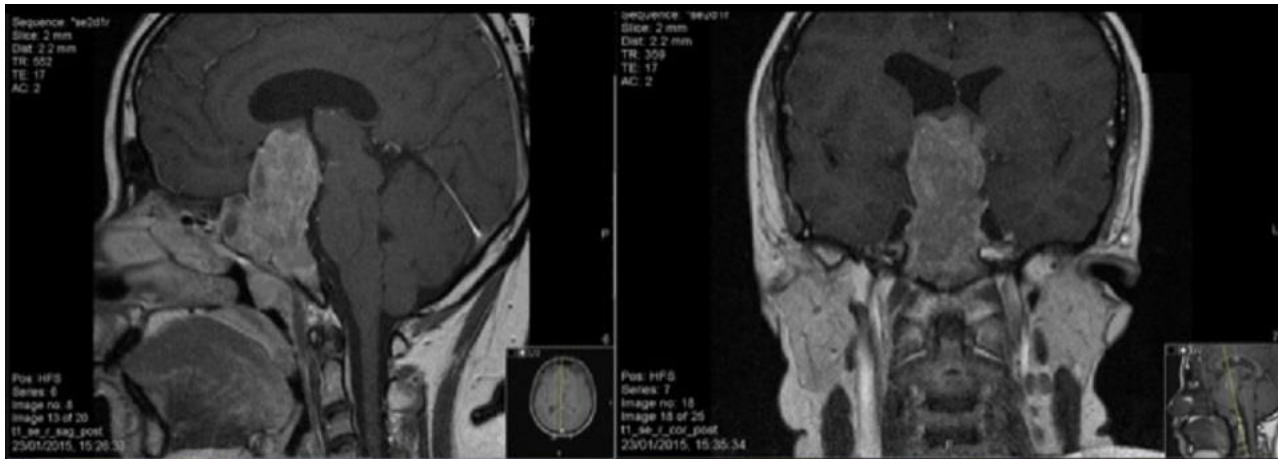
Sagittal view T1 weighted MRI pituitary demonstrating a large pituitary macroadenoma (56 x 40 x 28mm) with hydrocephalus
